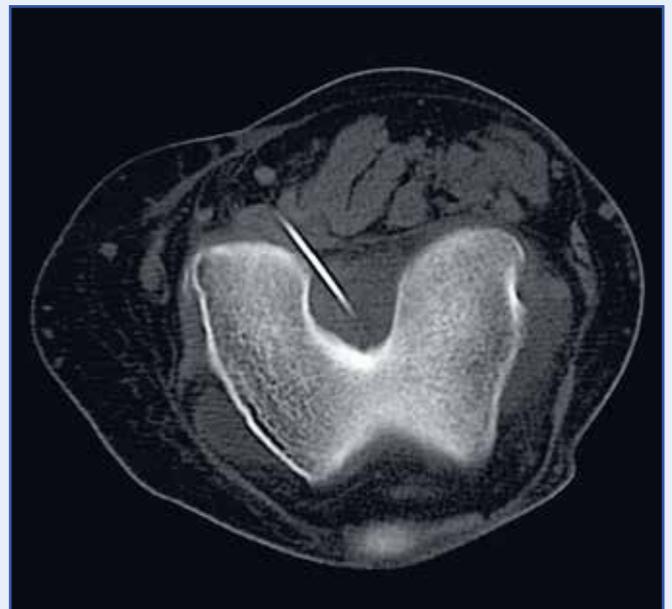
CT image showing needle placed in the ACL in intercondylar notch
